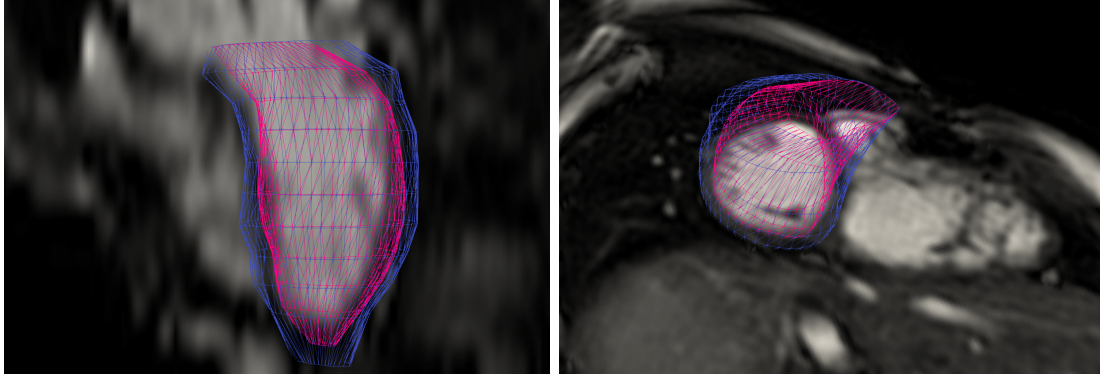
Example of the segmented endocardial (pink) and epicardial (blue) LV surface mesh overlaid over two sections through the stack of short-axis MRI cine.
